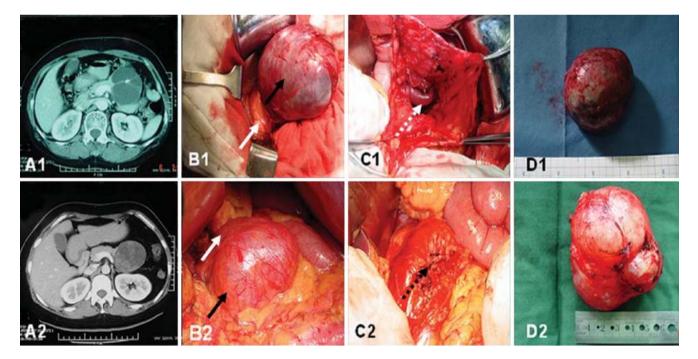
Demonstration of two cases of mucinous cystadenoma in the pancreatic body. A1–2, Preoperative views of the tumors in CT scan in two different cases. B1–2, Intraoperative views of the tumors of the two respective cases, pancreas (*white arrows*) and cystadenomas can be seen (*black arrows*). C1–2, Views of the corresponding
